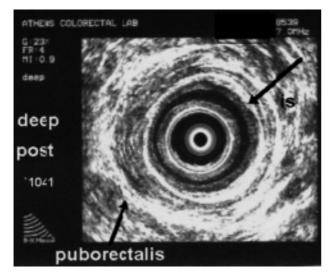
Normal endosonogram of anal canal at the deep level. The puborectalis and the internal sphincter are visualized (right side of the figure represents the 6th hour at lithotomy position, upper side represents the 9th hour).
